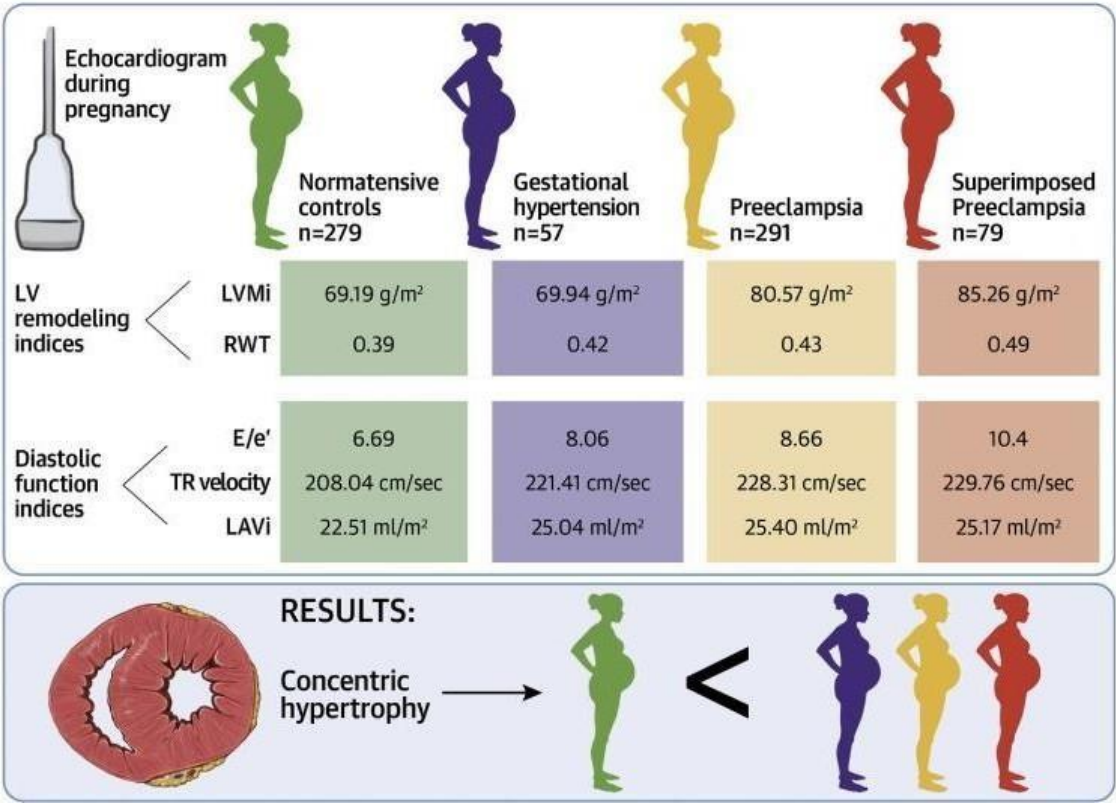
FIGURE NO 11. Echocardiographic Changes in Women across different subtypes of Hypertensive Disorder of Pregnancy.
